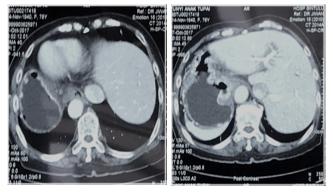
Computed tomography showing a) tumour at the esophagogastric junction (arrow), b) exophytic tumour with enlarged perigastric node.
